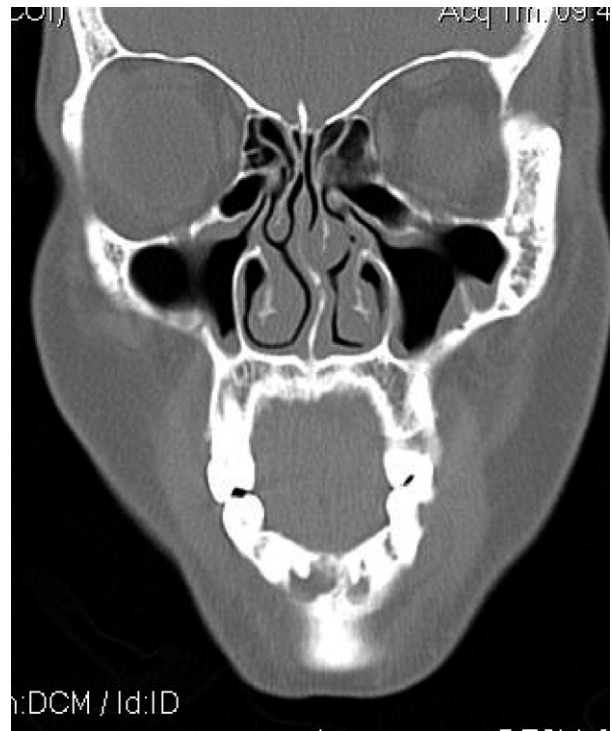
Coronal computed tomography image of symphyseal lesions.
